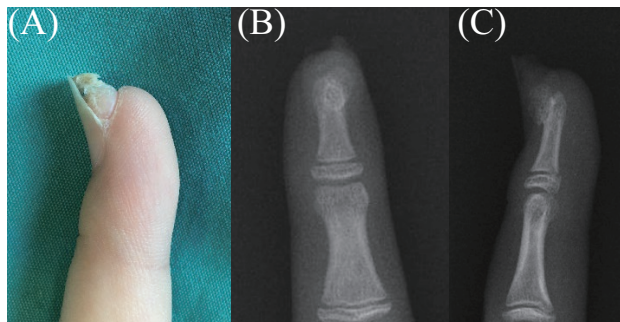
Clinical photos and radiographs of subungual exostosis in the right index finger of an 8-year-old girl. (A) Clinical photos, (B) posteroanterior and (C) lateral radiographs, of the lesion.
